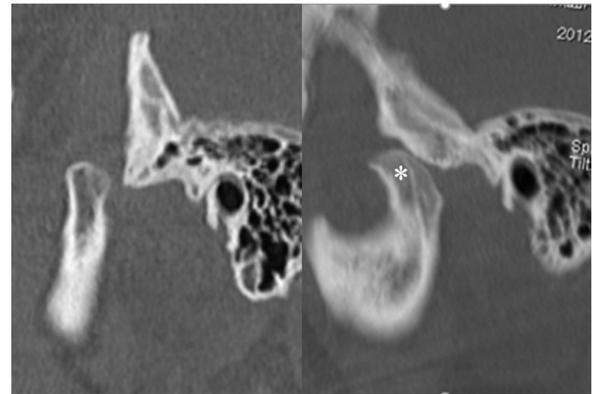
Incomplete reduction (case 9). Before (left) and after (right) computed tomography scans of long-standing dislocation of the left temporomandibular joint. The condyle (\*) is anterior to the mandibular fossa after eminectomy, discectomy, and condylectomy.
